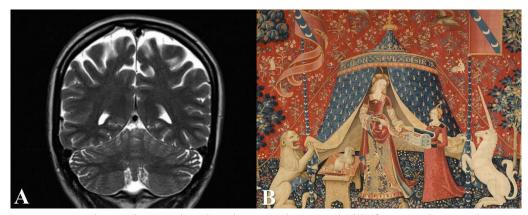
Coronal MRI image showing the tentorium cerebelli (from *Turliuc et al., 2017a*) (A). The Lady and the Unicorn, *Tapestry Cycle, late 15th century, National Museum of the Middle Ages, Paris* (public domain) (B).
